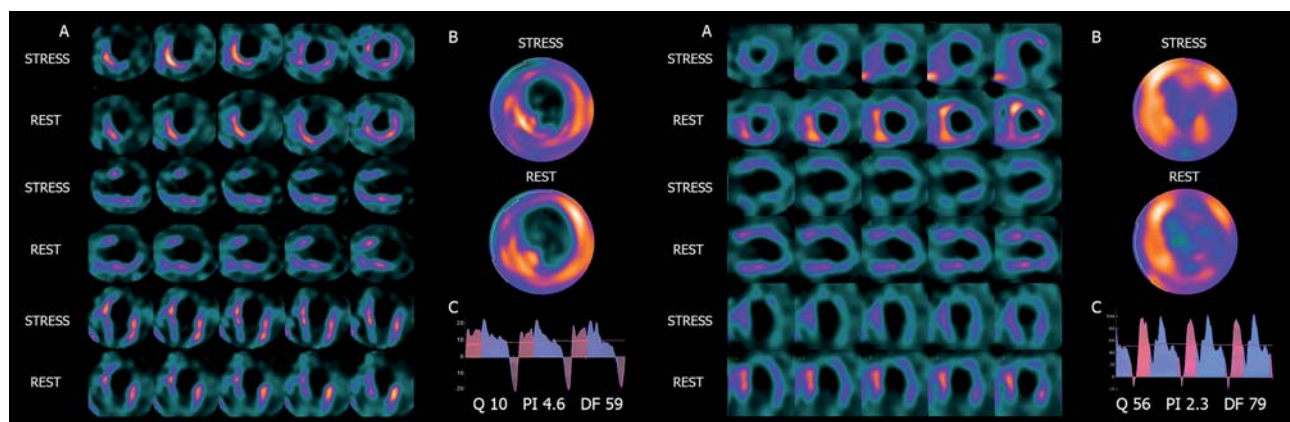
The myocardial perfusion stress-rest SPECT (A, B) in ischemic cardiomyopathy patients with non-satisfactory ($Q < 11.5$, left) and satisfactory ($Q > 11.5$, right) flow in left internal mammary artery grafts during coronary artery bypass grafting (C).
